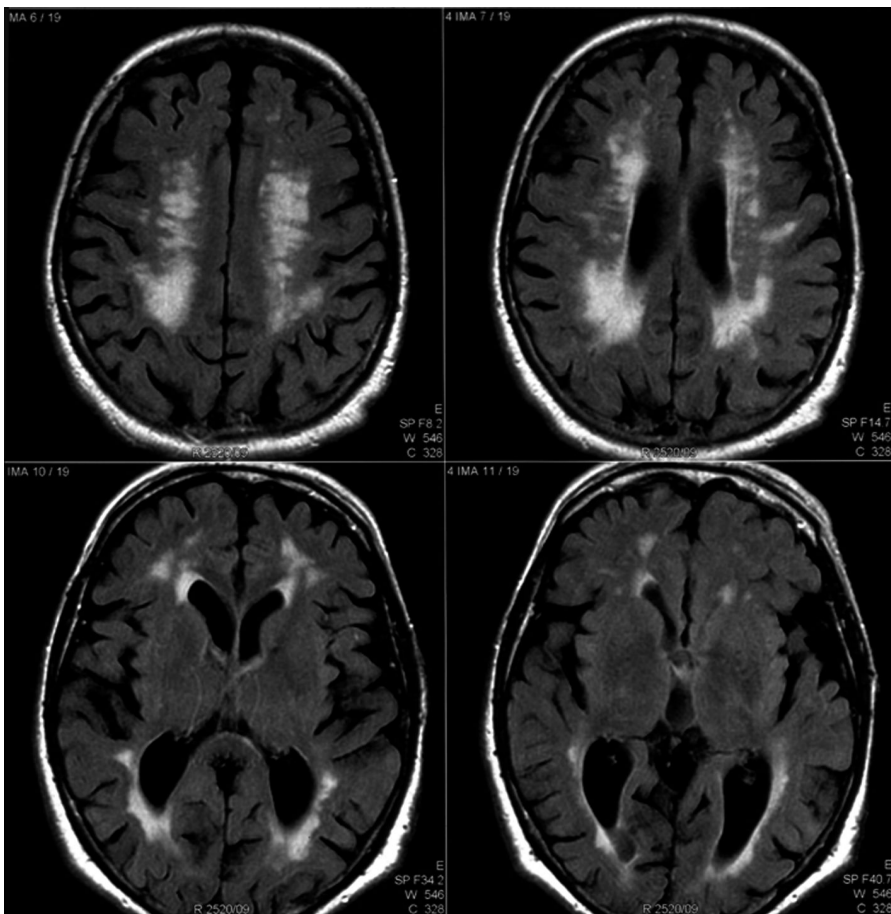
Advanced subcortical vascular encephalopathy on a magnetic resonance imaging of the brain in a patient with both dementia and recurrent tonic-clonic seizures.
